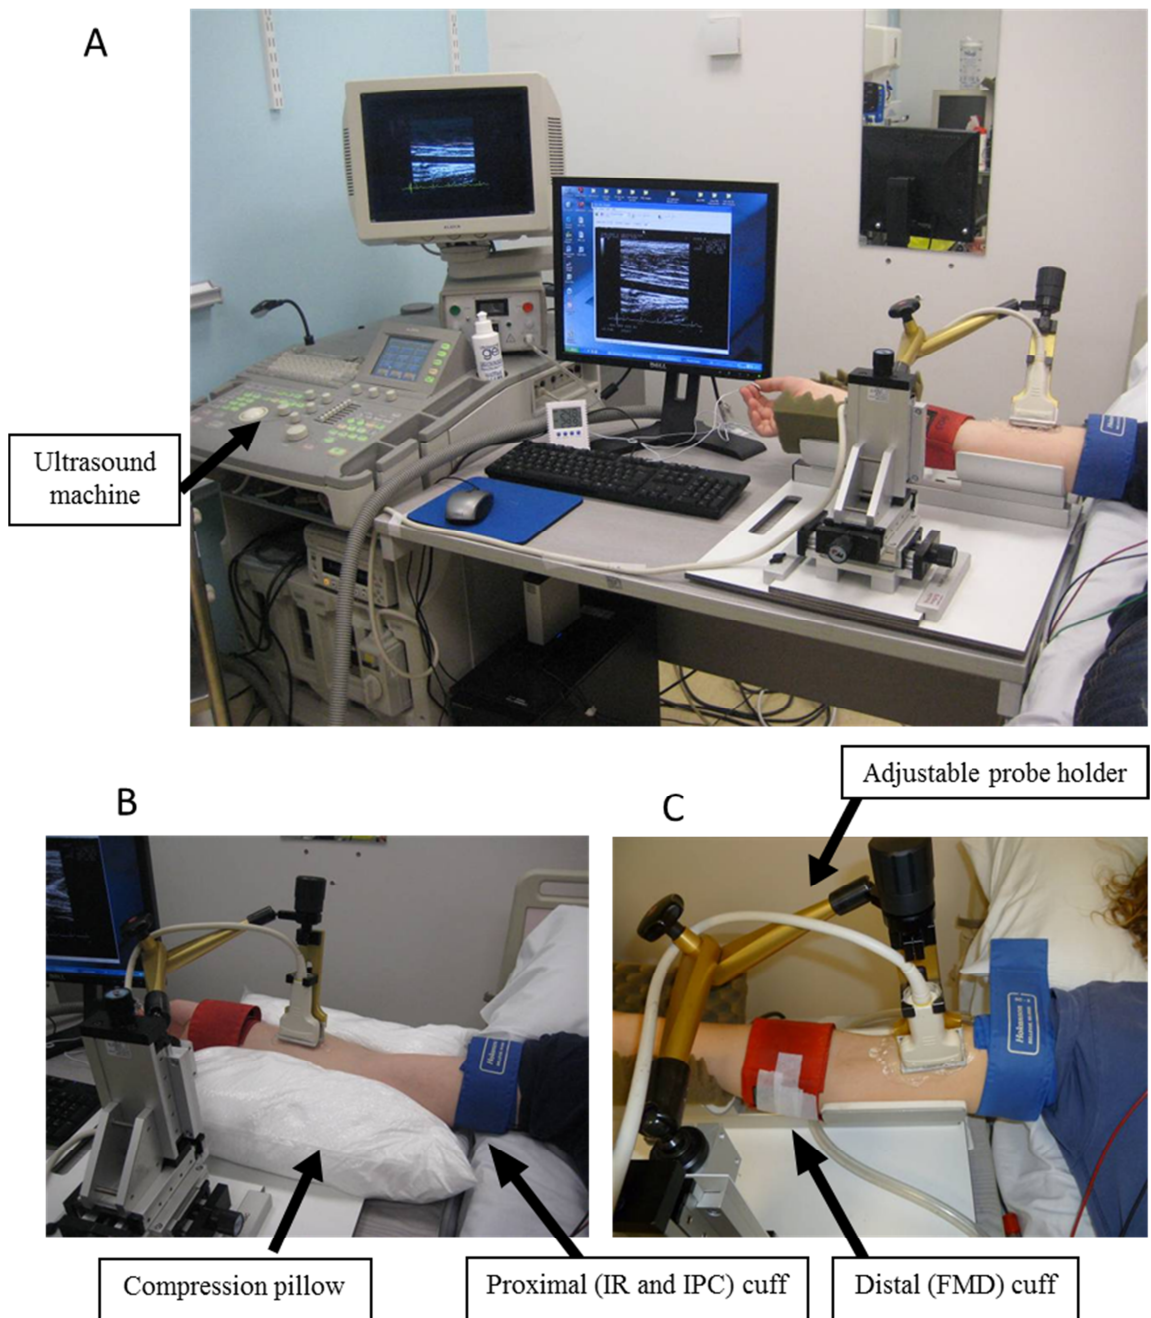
Experimental set up for vascular ultrasound studies. Subjects laid supine whilst the right arm was imaged (A). The FMD cuff was applied below the medial epicondyle for the FMD protocol. A proximal cuff was fitted below the shoulder for inducing IR and IPC. In the radial studies a compression pillow maintained arm stability (B), whilst in the brachial studies the arm was supported by an arm holder and foam pad (C).
